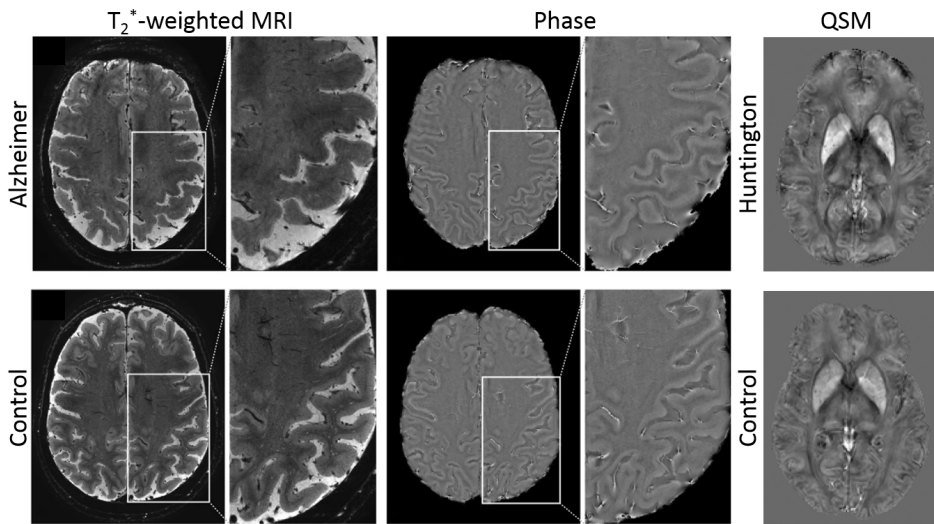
Susceptibility-weighted MRI in patients with Alzheimer's and Huntington's disease. Phase images show enhanced contrast between cortical gray and white matter in AD patients compared to control subjects, indicating a larger cortical phase shift. QSM shows significant susceptibility differences within the striatum of HD patients compared to control subjects. Figure adapted from van Rooden, et al., 2014 [26] and van Bergen et al., 2016 [48]
